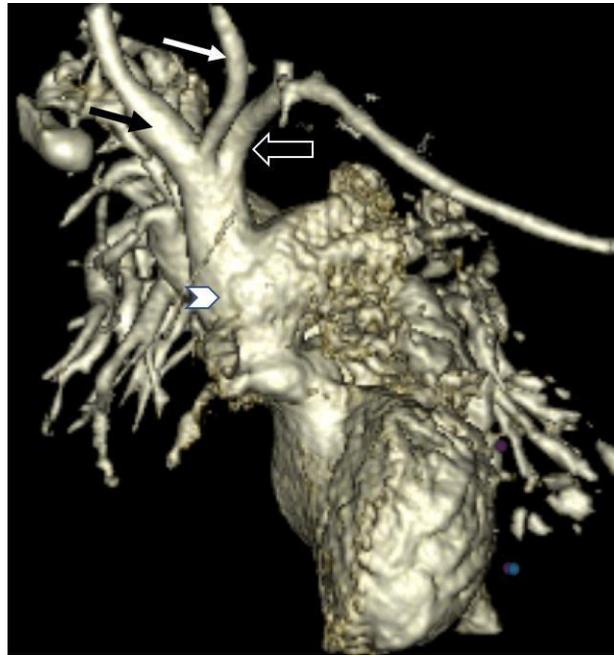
CT Angiography (CTA) of a 4-month-old boy patient at the 3D image of cardiac and great vascular showing the right brachiocephalic trunk (black arrow), left common carotid artery (white arrow), and left subclavian artery (empty arrow). An AP Window image at the sinotubular junction with MPA (head arrow)
